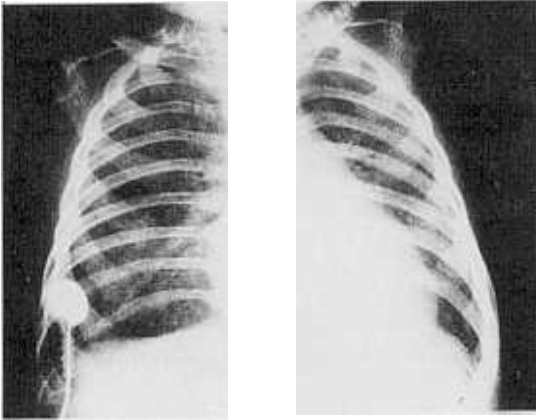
A chest x-ray of this case on the 44th hospital day before discharge shows almost normal findings.
